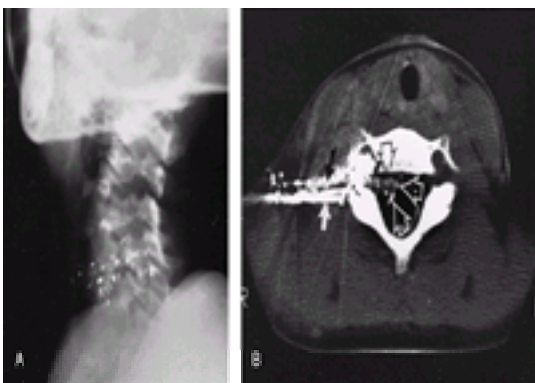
Gunshot wound (0.22 caliber) to the neck in a 5-year-old girl. A. Lateral neck radiograph showing fragmentation of bullet along path. B. Computed tomography scan of same patient demonstrating bullet fragments in and around spinal canal, as well as cerebrospinal fluid and contrast leak from disruption of the dura.
